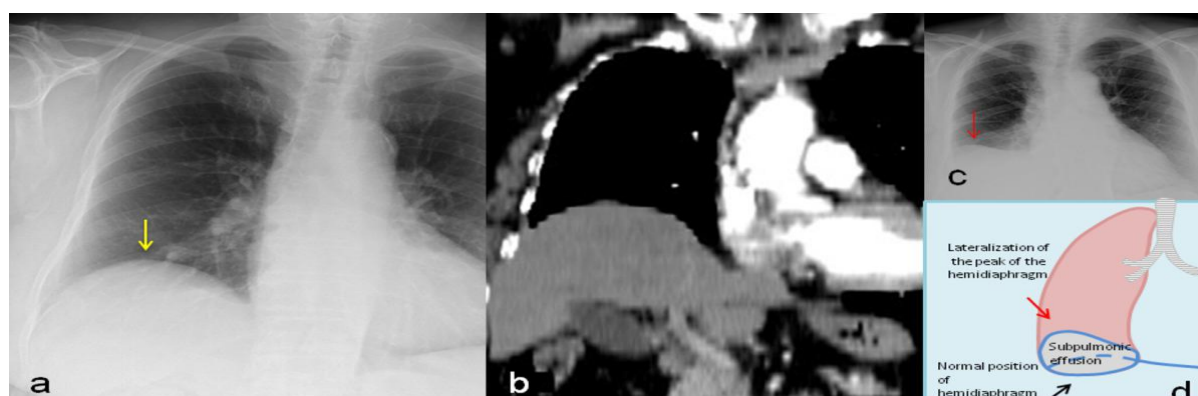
Frontal (a) chest radiograph and coronal MPR reconstruction (b) in an 83-year-old woman showing elevation of the right hemidiaphragm (yellow arrows in a,b). Figure (c) and the scheme (d) show radiological findings of subpulmonic pleural effusion; in subpulmonic pleural effusion there is an apparent elevation of the right hemidiaphragm with a peak more lateral than usually (red arrows).
